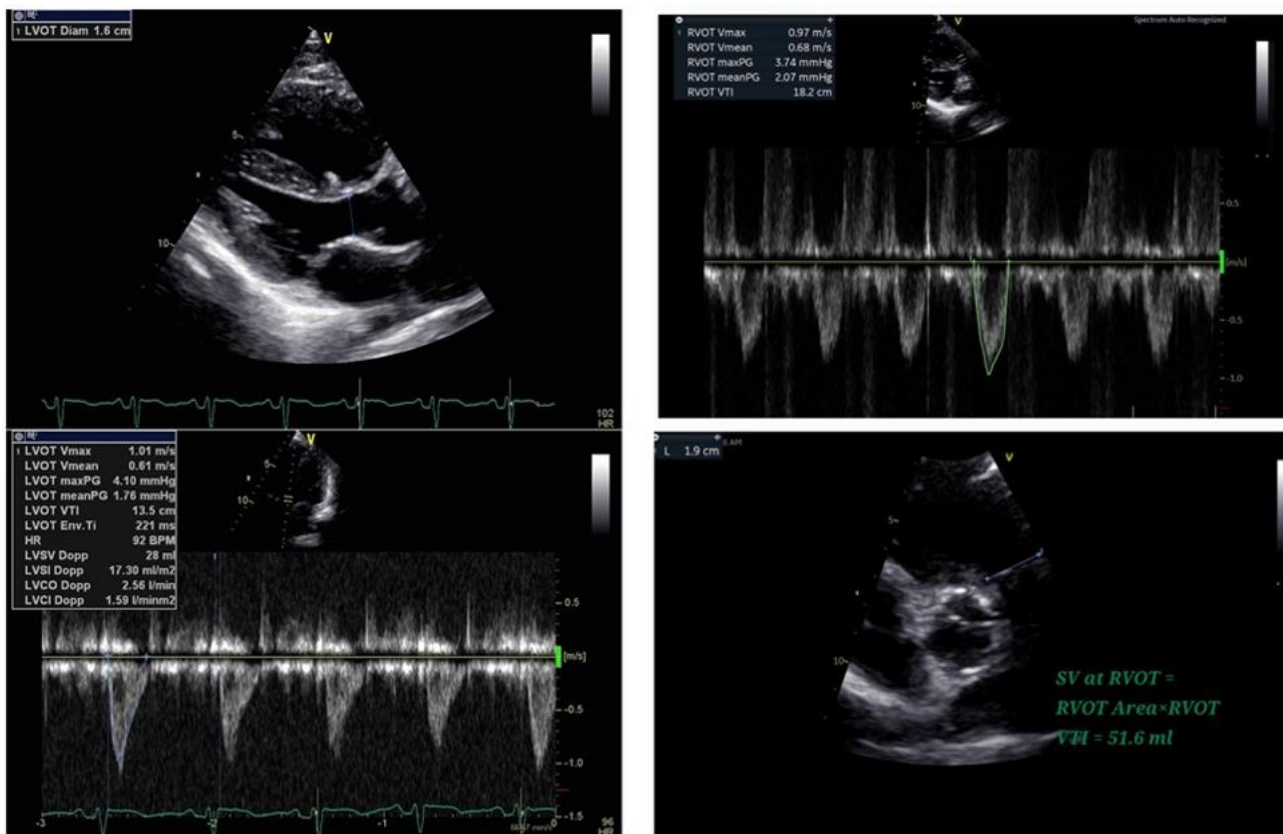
Echocardiography-derived pulmonary-to-systemic flow ratio calculation. The calculation was done from obtained measurements, as follows: (A) pulmonary blood flow (Q_p)—measure cross-sectional area of right ventricular outflow tract (RVOT), measure velocity of blood flow across RVOT using Doppler echocardiography, & calculate (Q_p) using $Q_p = CSA (RVOT) \times VTI (RVOT)$; (B) systemic blood flow (Q_s)—measure cross-sectional area of the left ventricular outflow tract (LVOT), measure the velocity of blood flow across the LVOT using Doppler echocardiography, calculate (Q_s) using $Q_s = CSA (LVOT) \times VTI (LVOT)$; (C) calculate the ratio Q_p/Q_s —once you have Q_p and Q_s values, calculate $Q_p/Q_s = \text{Pulmonary blood flow/systemic blood flow}$; & (D) interpret the results—A Q_p/Q_s ratio greater than 1 indicates increased pulmonary flow, while a ratio of less than 1 suggests decreased pulmonary flow relative to systemic flow (this approach provides a non-invasive approach to assess the pulmonary and systemic blood flow dynamics in patients) (CSA: Cross-sectional area in cm^2 & VTI: Velocity time interval in cm) (Calculate LVOT SV = LVOT area \times LVOT VTI = 28 ml & $q_p/q_s = 51.6/28 = 1.84$) (reprinted with permission of the patient)
